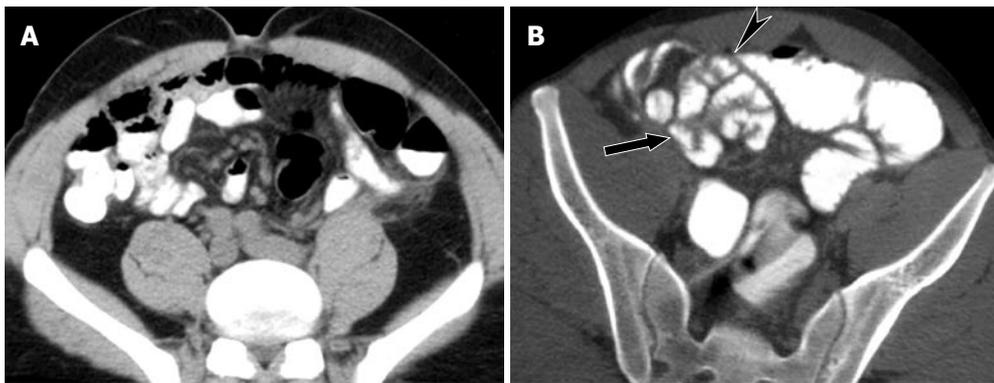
Fifty-four years old with prior hysterectomy presented with abdominal bloating and nausea. A: Conventional CT did not show distended bowel or transition point and was interpreted as normal; B: CT enteroclysis performed a day later shows distended small bowel loop with beaking (arrowhead) adjacent to anterior parietal peritoneum. Distal small bowel loops were nondistended (arrow). The appearances were of low grade small bowel obstruction due to adhesions.
